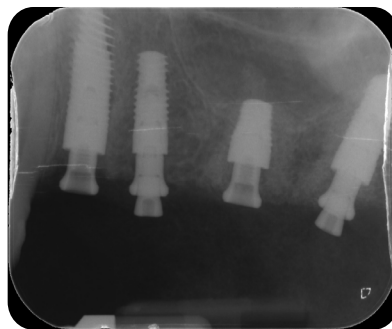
Intraoral X-rays showing the GFA in place.*
